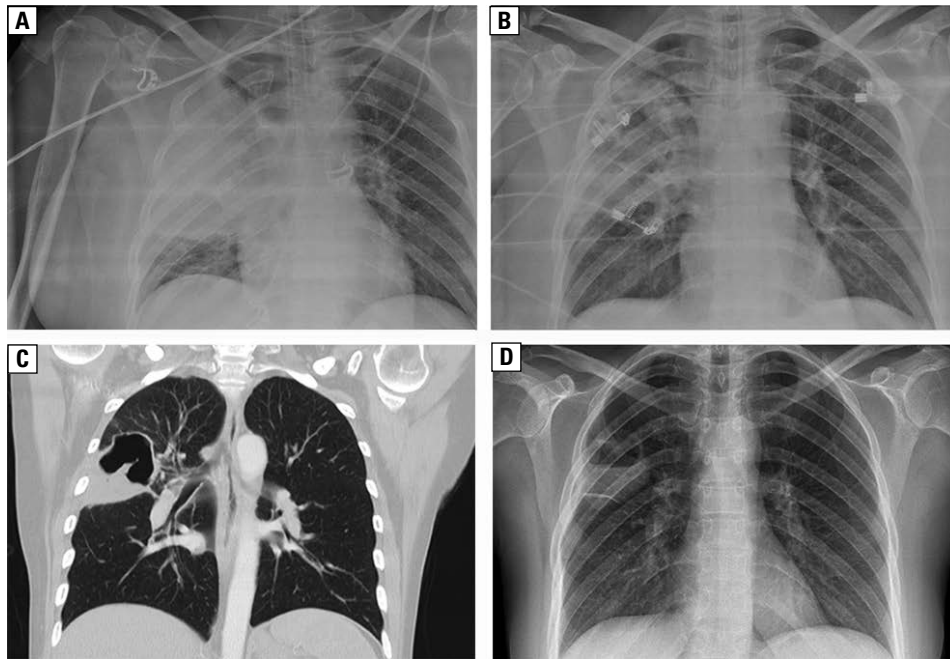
A — chest X-ray. Large consolidation in medium-upper zone of the right lung; B — chest X-ray. Large consolidation and cavitation inside; C — chest computed tomography (coronal reconstruction) at day 18: cavitation with thick walls and irregular inner edges; D — chest X-ray at discharge: further reduction of the cavitation in the upper pulmonary lobe
